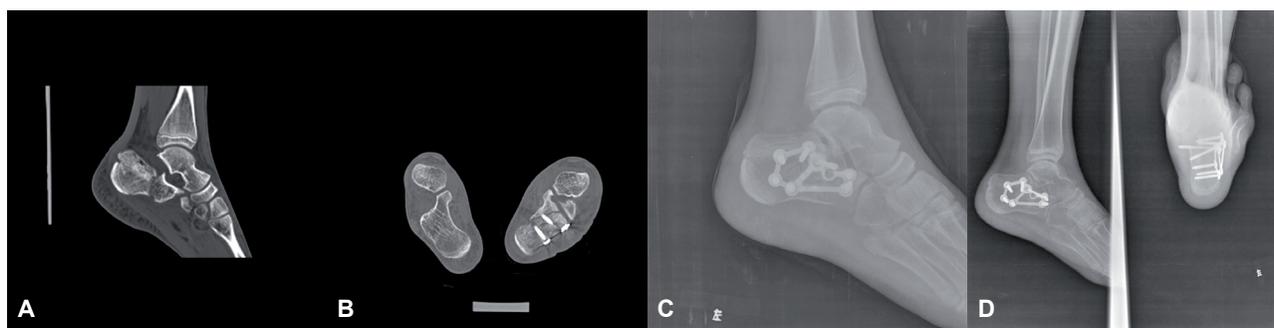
An 11-year-old boy with trauma to the left foot in a traffic accident. Computed tomography scan showing that Bohler's angle and Gissane's angle was decreased and the posterior subtalar joint surface was comminuted. 2B-2C, Immediate postoperative radiograph and Computed tomography scan demonstrating restoration of Bohler's angle and Gissane's angle. 2D, ten-month radiograph demonstrating that the fracture had healed and that Bohler's angle and Gissane's angle was normal.
